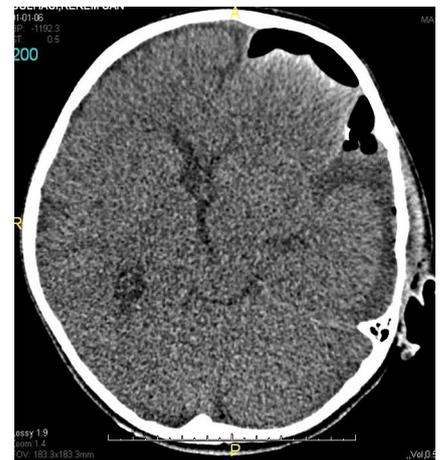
Postoperative CT scan showed the absence of the subdural hematoma and intracystic hematoma.
